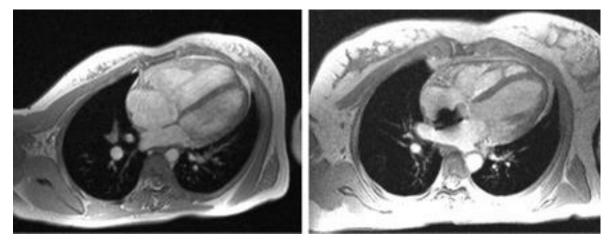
Cardiac MRI showing right heart remodeling after closure of a secundum ASD with an Amplatzer device.
